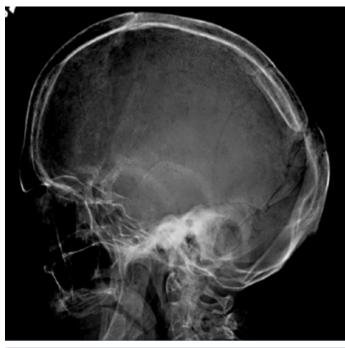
Sagittal skull radiograph showing wormian skull bones
